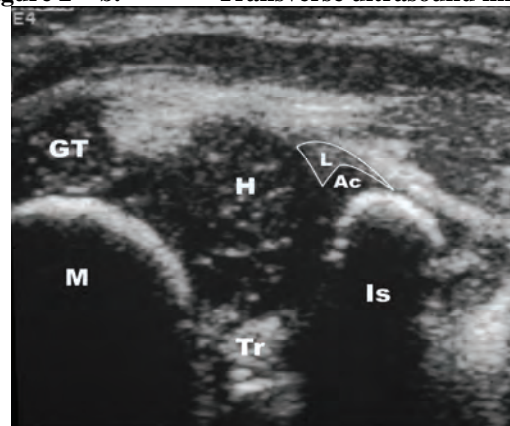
b. Transverse ultrasound image
